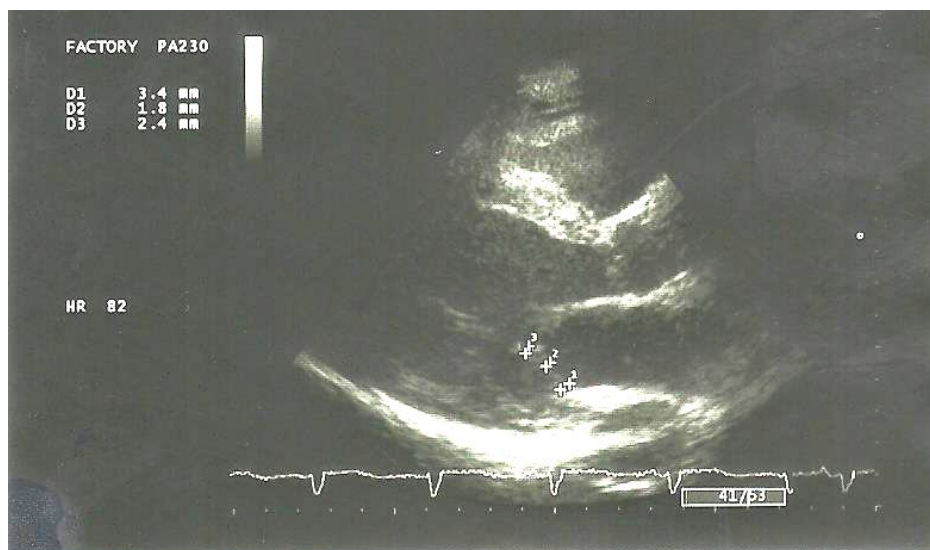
Parasternal long axial view of posterior leaflet.
